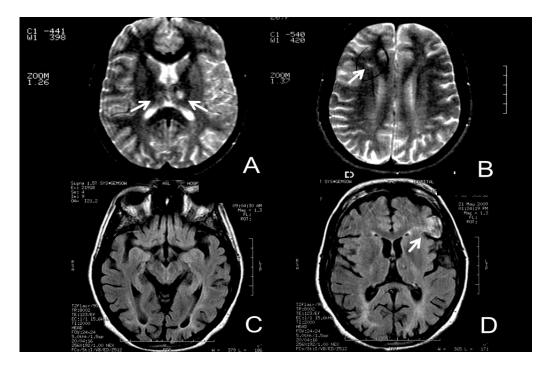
Cranial magnetic resonance imaging scan (T2 and T2 fluid-attenuated inversion recovery [FLAIR] sequences) showed: (A) an acute bilateral thalamic stroke (white arrows); (B) an acute right frontal stroke (white arrow); (C) a severe cerebral global atrophy; and (D) a severe cerebral atrophy with an acute left frontal stroke (white arrow)
